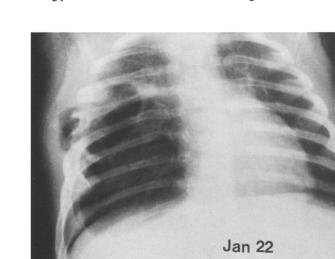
Case 2. Chest radiograph three and a half weeks earlier than Figure 3. There is a soft tissue swelling in the right chest wall. The arrows point at a minimal adjacent pleural thickening
